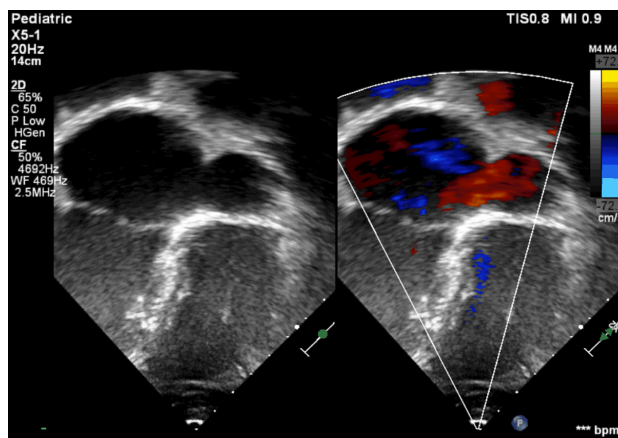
12-year-old male patient with Raghieb syndrome admitted in “Maria Skłodowska Curie” Emergency Children’s Hospital (Bucharest, Romania) with unroofed coronary sinus associated with persistent left superior – transthoracic echocardiography in apical four chambers showing dilated right chambers and dilated coronary sinus.
